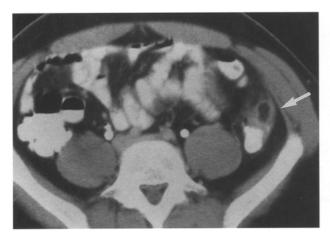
CT of the abdomen shows low attenuation mass (*arrow*) in the anterolateral surface of the descending colon with stranding of the mesentery around it. Within the center of the lesion, gas bubbles are seen due to infarcted appendices epiploicae.
